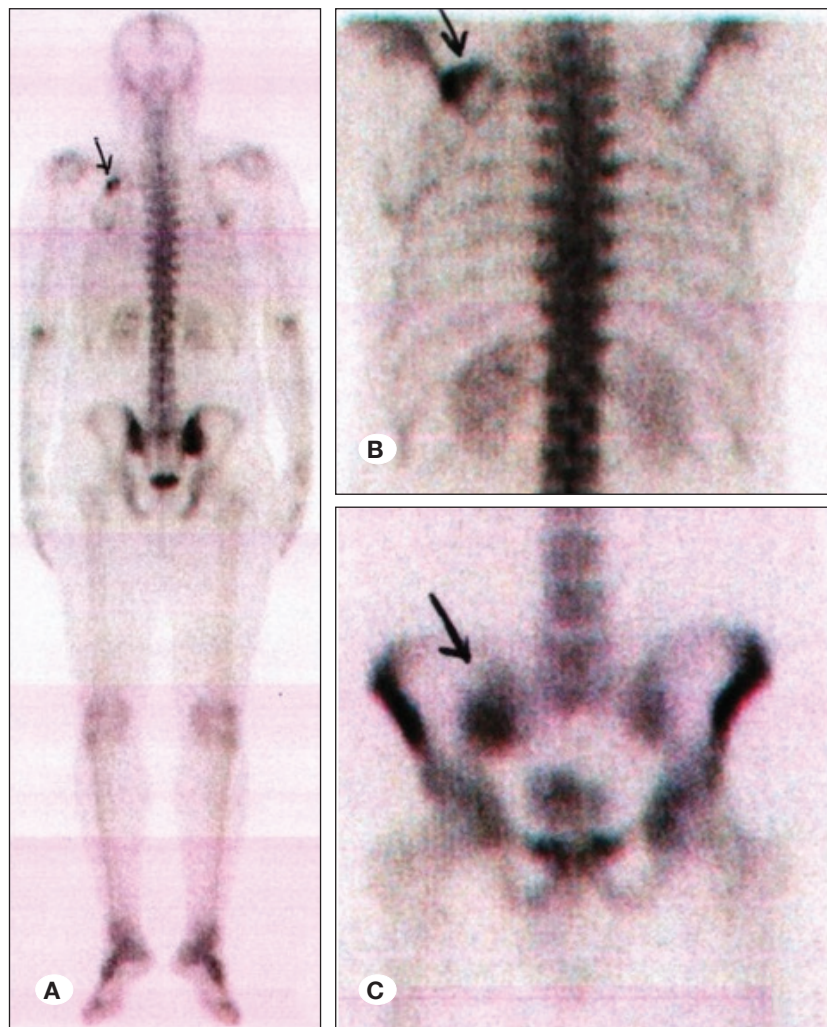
Postoperative whole body scintigraphy. Increased activity at the posterolateral part of the left 2nd costa (A, B), and right sacroiliac joint (C).
